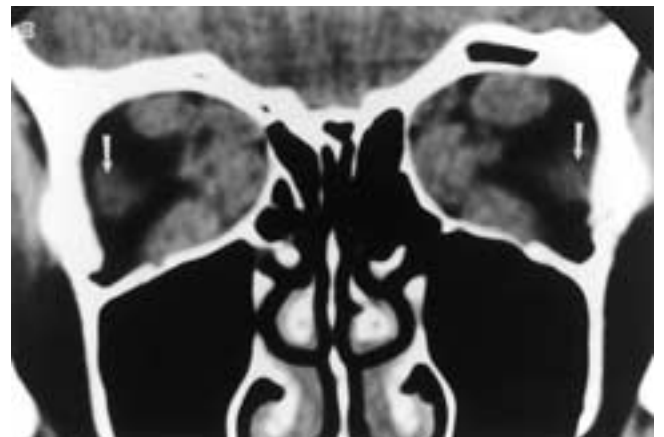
Thyroid ophthalmopathy in a 43-year-old woman with Graves' disease. Coronal CT scan shows bilaterally symmetric enlargement of the bellies of the extraocular muscles, with relative sparing of the lateral rectus muscles (arrows).
